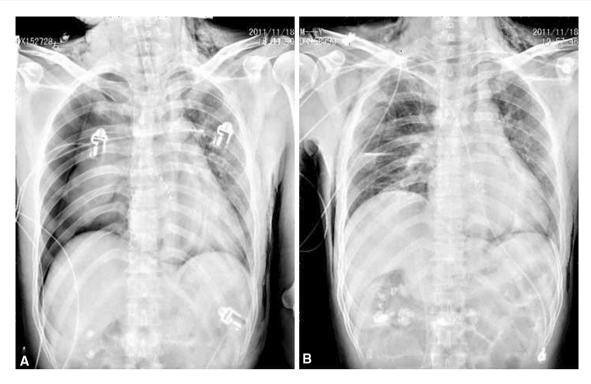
The occurrence of pneumothorax in a 53-year-old male patient. A X-ray examination verified the occurrence of pneumothorax in the right chest after POEM procedure; B after thoracic drainage using chest tube for 1 week, he recovered satisfactorily
